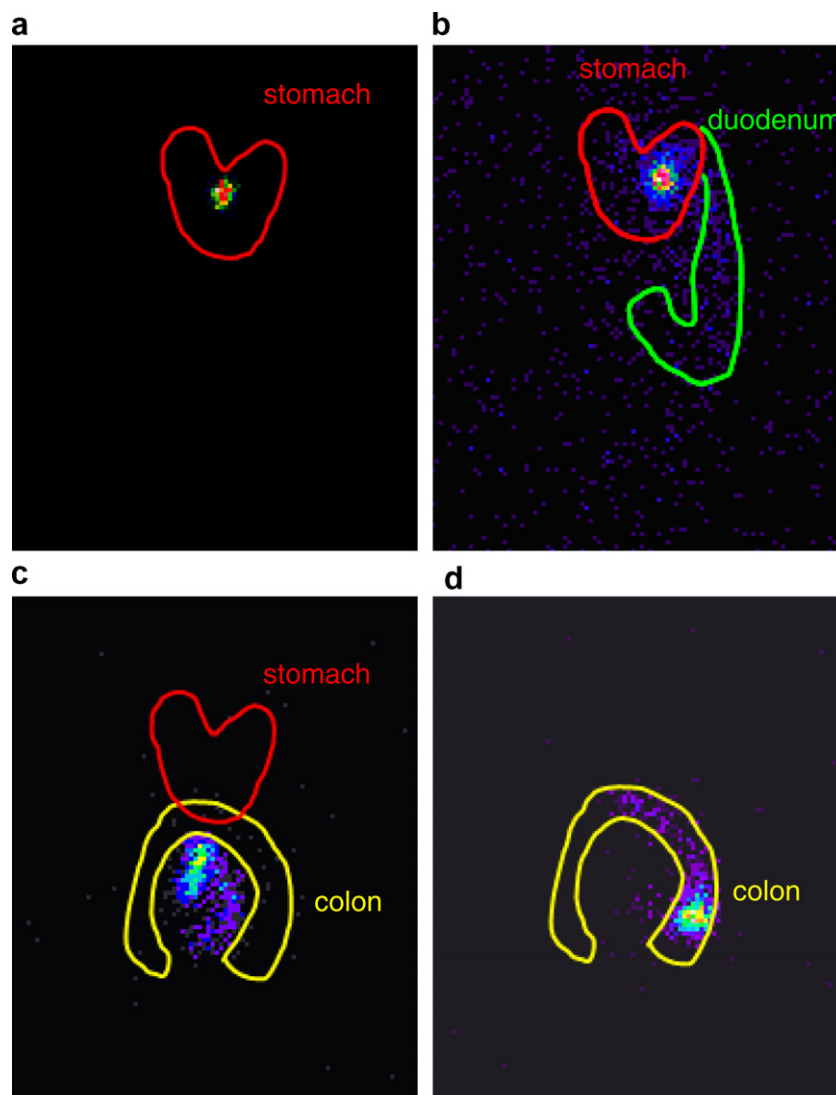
Representative gamma scintigraphic images showing intact HPCT in stomach (a), and disintegrating HPCT in stomach (b), small intestine (c) and colon (d).
